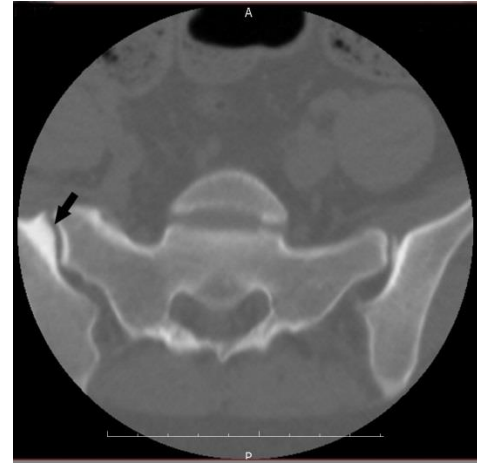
Right sided osteitis condensans ilii in a 18 year old female patient. Computed tomography shows triangular shaped sclerosis around the lower part of the right sacroiliac joint (thick arrow).
